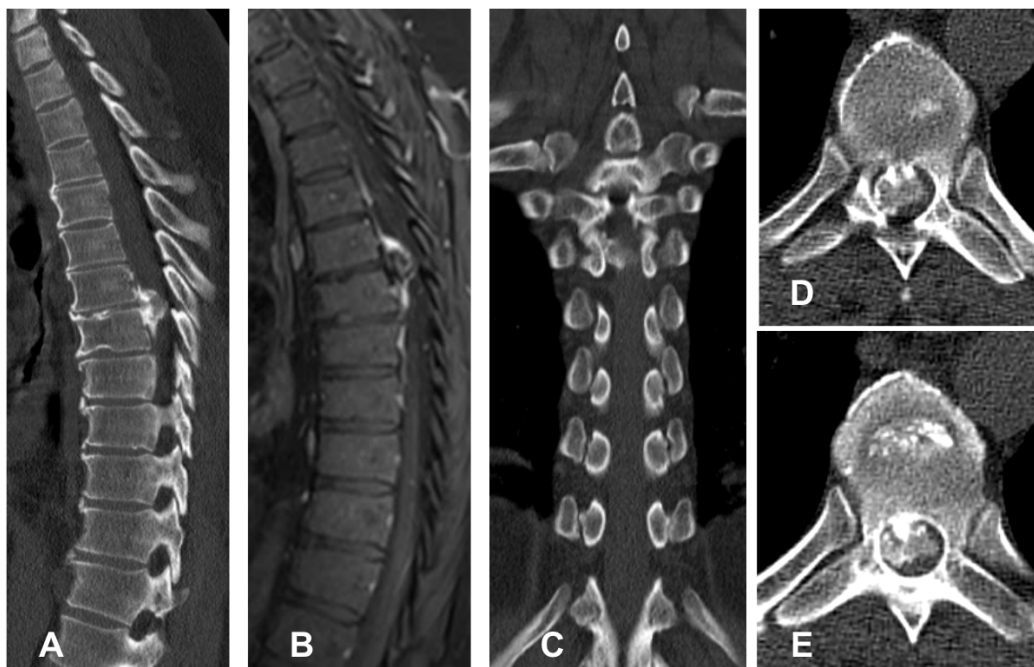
CT scan of the dorsal spine, with sagittal (A and B), coronal (C), and axial (D and E) section: osteochondroma in the spinal canal at the level of T7.
